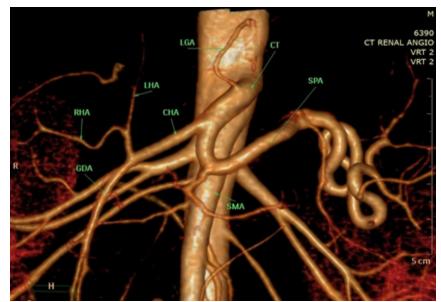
CT Angiogram, volume rendered image showing normal Coeliac Artery and hepatic artery branching with Early Branching of Left Gastric Artery.
